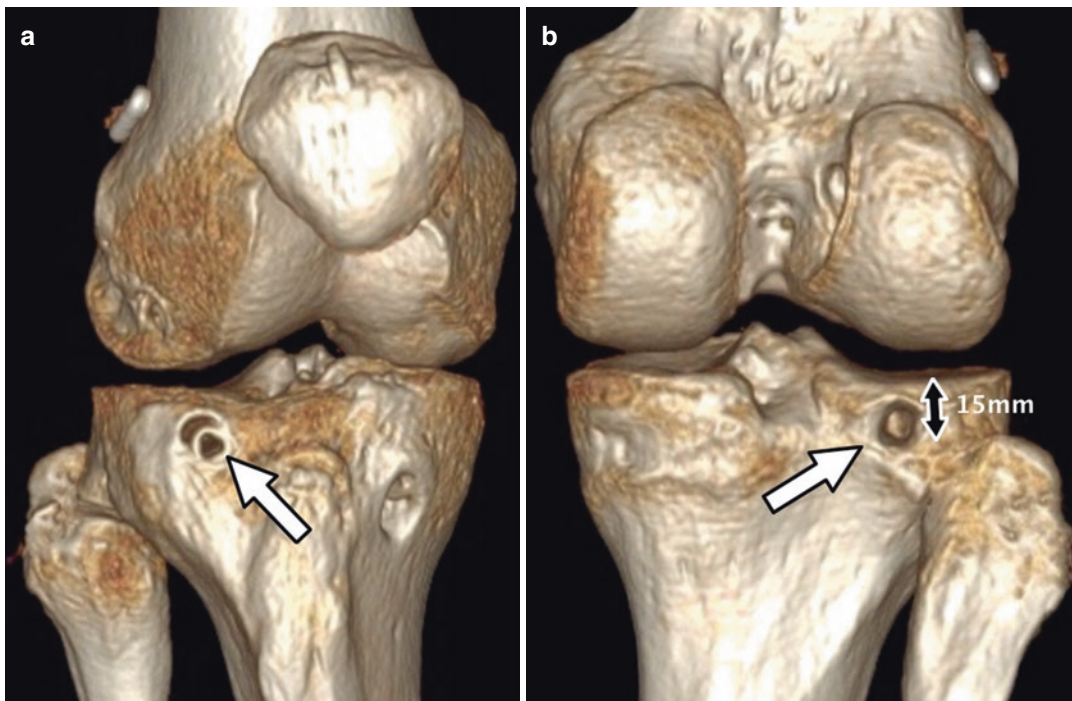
Postoperative 3D CT scan of a right knee. (a) anterior view; the entry point of the tibial tunnel (arrow) is seen right medial to Gerdy's tubercle. (b) posterior view;
